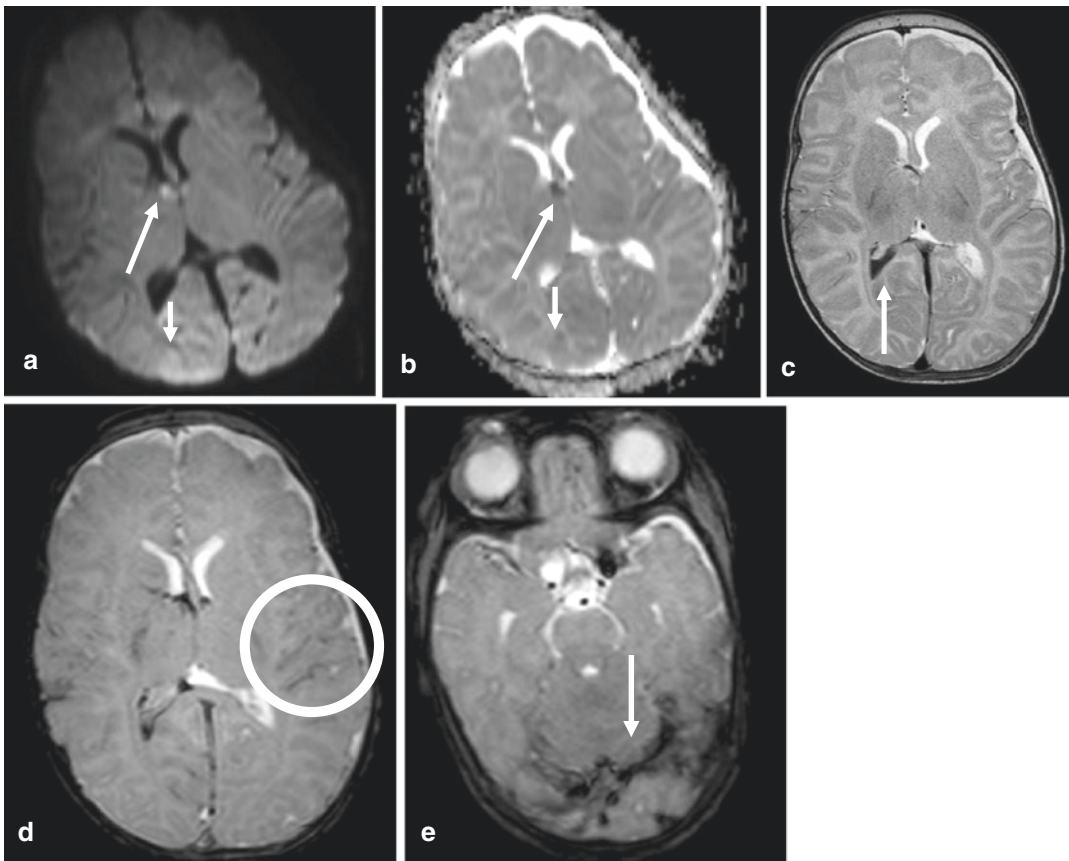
(a–e) Four-month-old male child after nonaccidental trauma shows DAI with RD in the fornix (a is DWI and b is ADC) and IVH (c is T2 and d is GRE) and SDH (e is GRE) along the tentorium due to shaken baby
